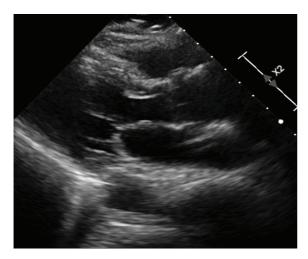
Normal echocardiogram
